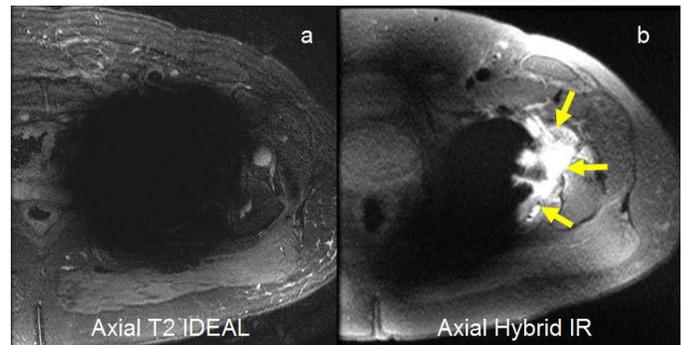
(a, b) Axial MR images in a 64 year old man with bilateral hip replacements and chronic hip pain demonstrate a large hip effusion, only clearly seen on Hybrid (arrows). The patient was subsequently managed conservatively.
